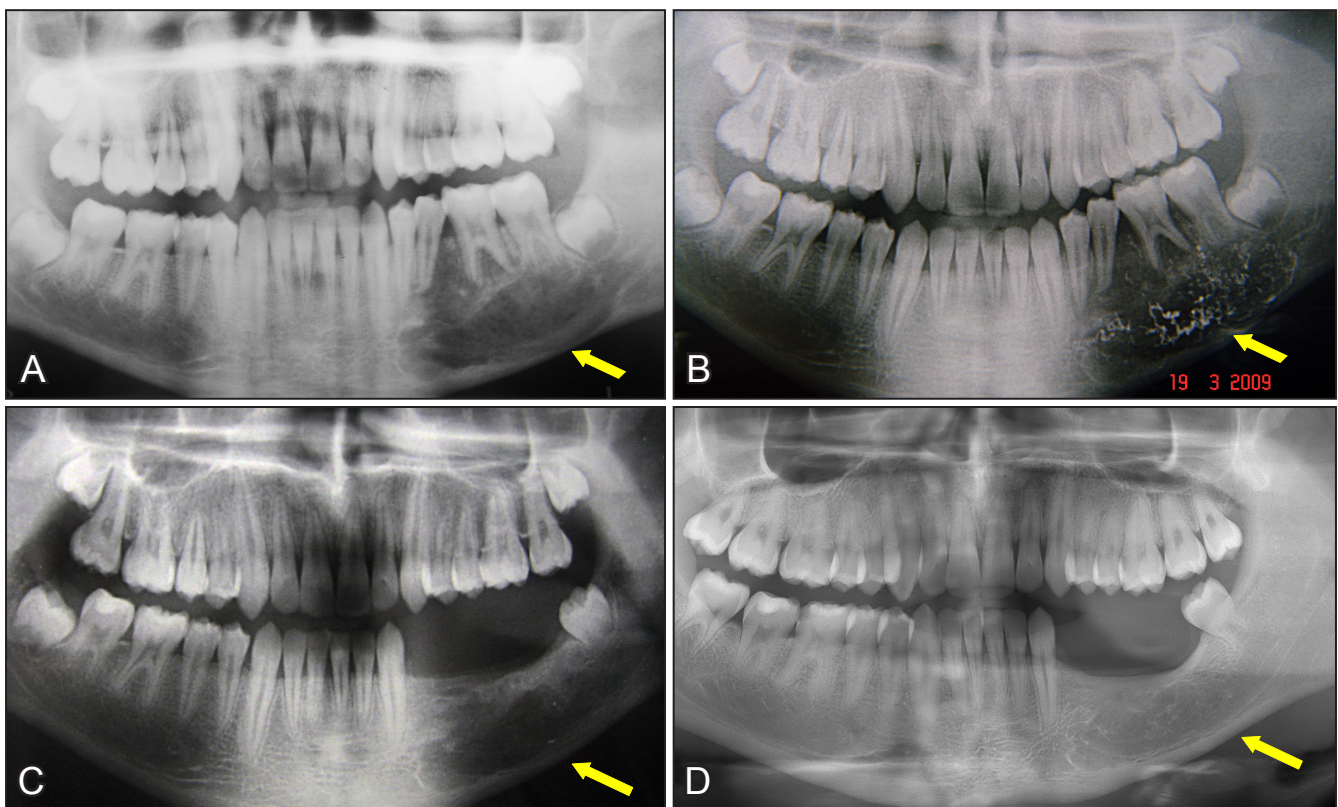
A = initial orthopantomogram of the patient number 1, showing an ill-defined IVA located at the left side of the mandibular body; B = orthopantomogram, directly after embolization with coils; C = 2 months after peripheral mandibulectomy; D = 5-years postoperatively, showing complete rehabilitation of the osseous defect.
